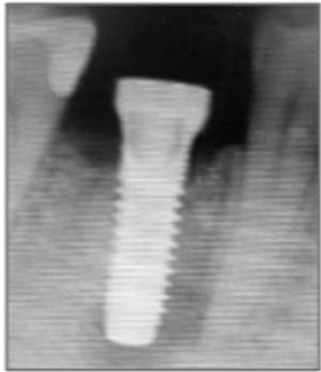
Follow-up radiograph
